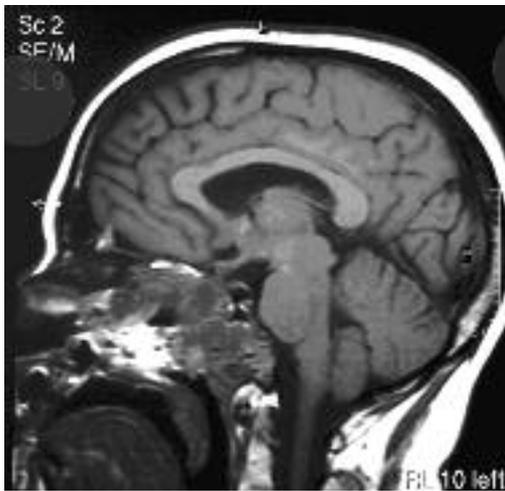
b Follow-up MRI: Comparison of pre and postoperative images: no signs of recurrence
